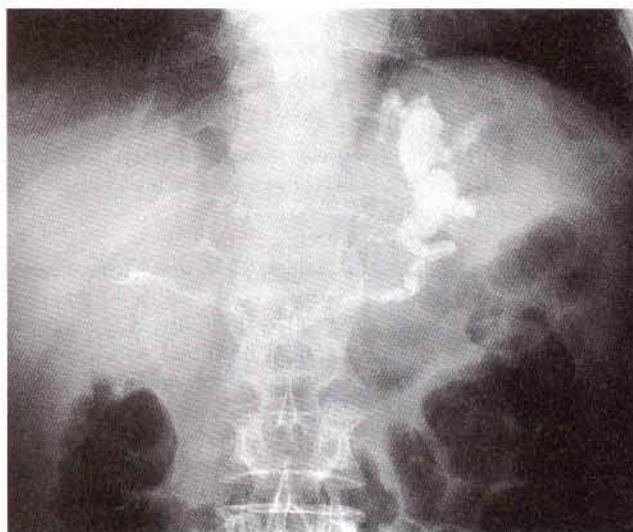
A linear radiopaque density is seen along the portal and splenic vein on a plain abdominal radiograph.
